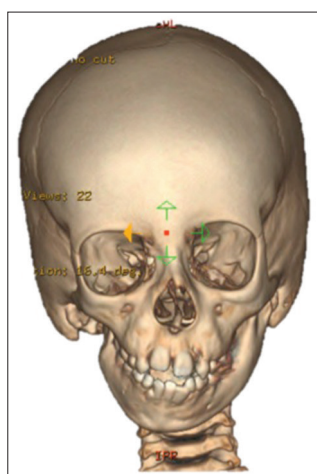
Three-dimensional (3D) reconstruction of a multi-slice computed tomography (CT) scan of the skull of an O1M2b, E1, N0, S1 case of hemifacial microsomia. The skeletal asymmetry in this case is due to the absence of the right-sided ascending ramus, with compensating downward growth of the skull base and orbit at the affected side
